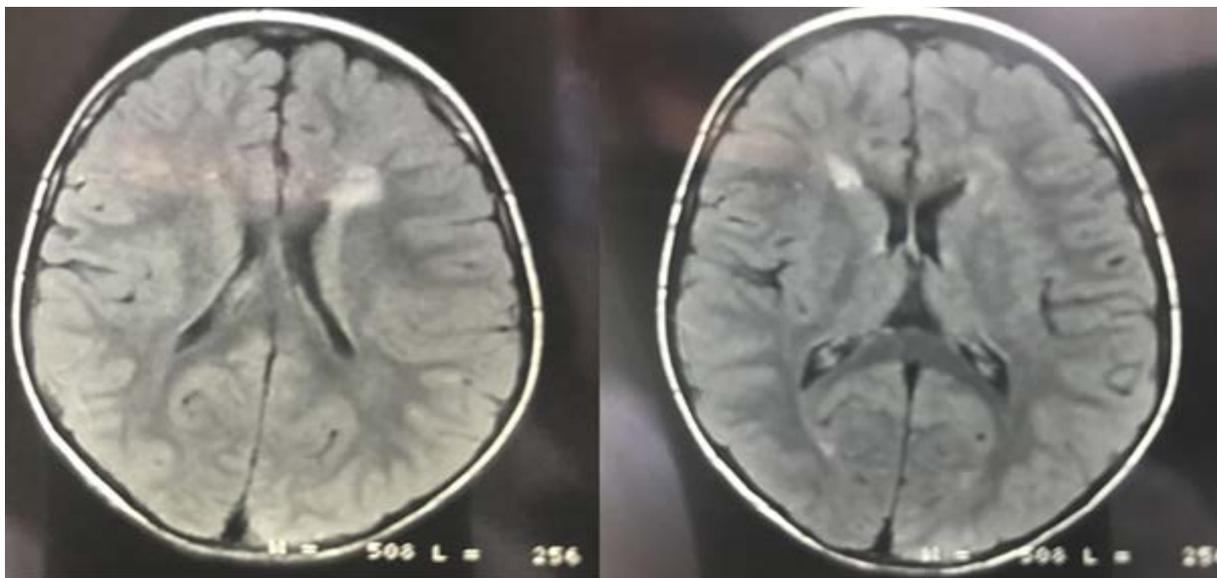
Brain MRI at 8 years old. In FLAIR sequences, it shows hyper signal intensity in white matter of right and left side
